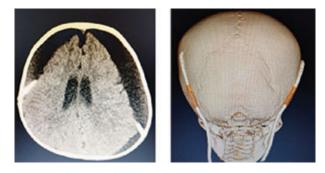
Postoperative CT scan of brain showing catheter in both subdural space
